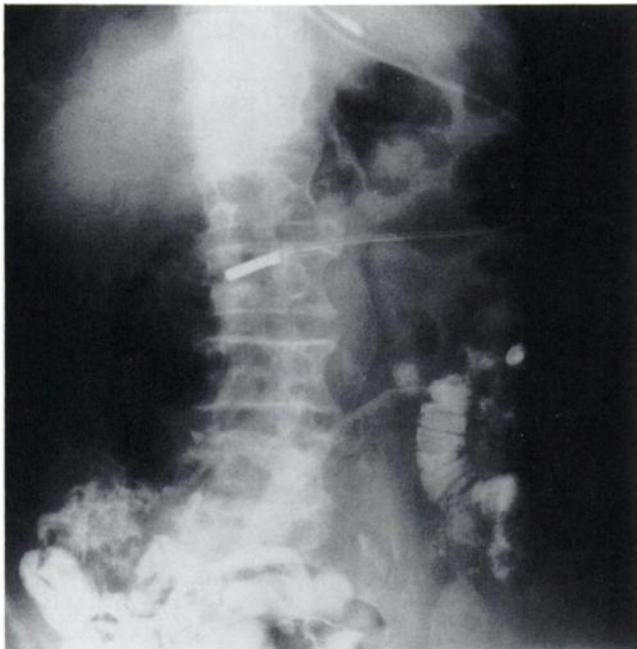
Supine abdominal x-ray demonstrating a 5-cm calcified abdominal aortic aneurysm.
